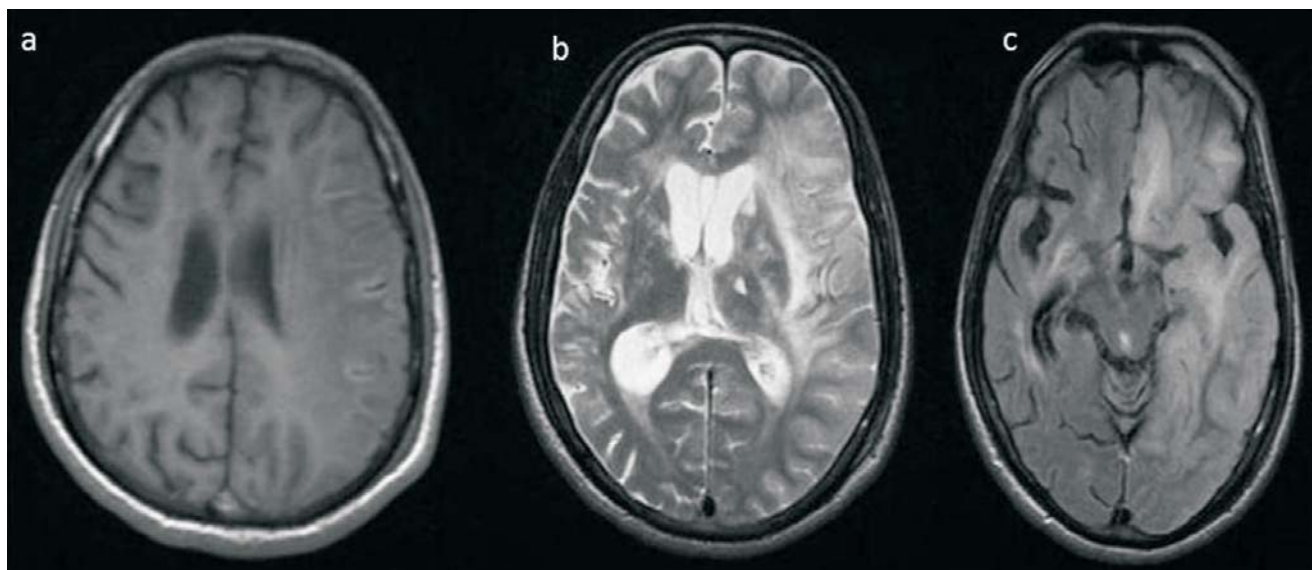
Axial MRI (a) T1-weighted; (b) T2-weighted; and (c) Fluid-attenuated inversion-recovery (FLAIR) images show diffuse hyperintensity in the left cerebral hemisphere on T2W and FLAIR sequences involving both gray and white matter with diffuse cortical thickening and effaced left lateral ventricle (c).
